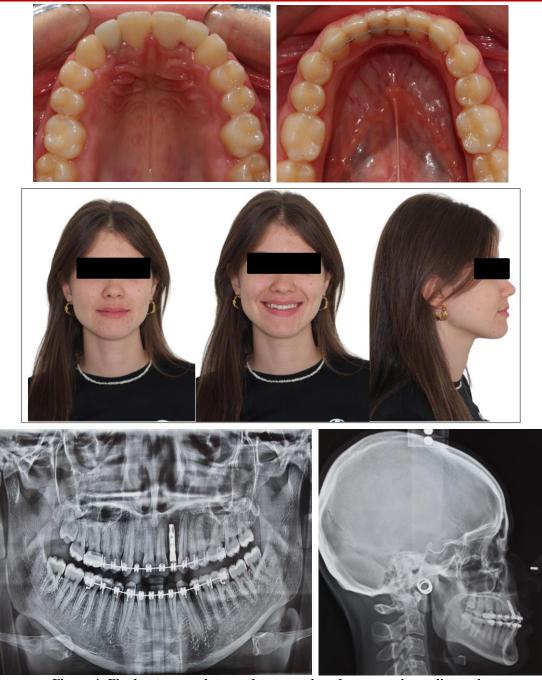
Final outcomes -intraoral, extraoral, and comparative radiographs
